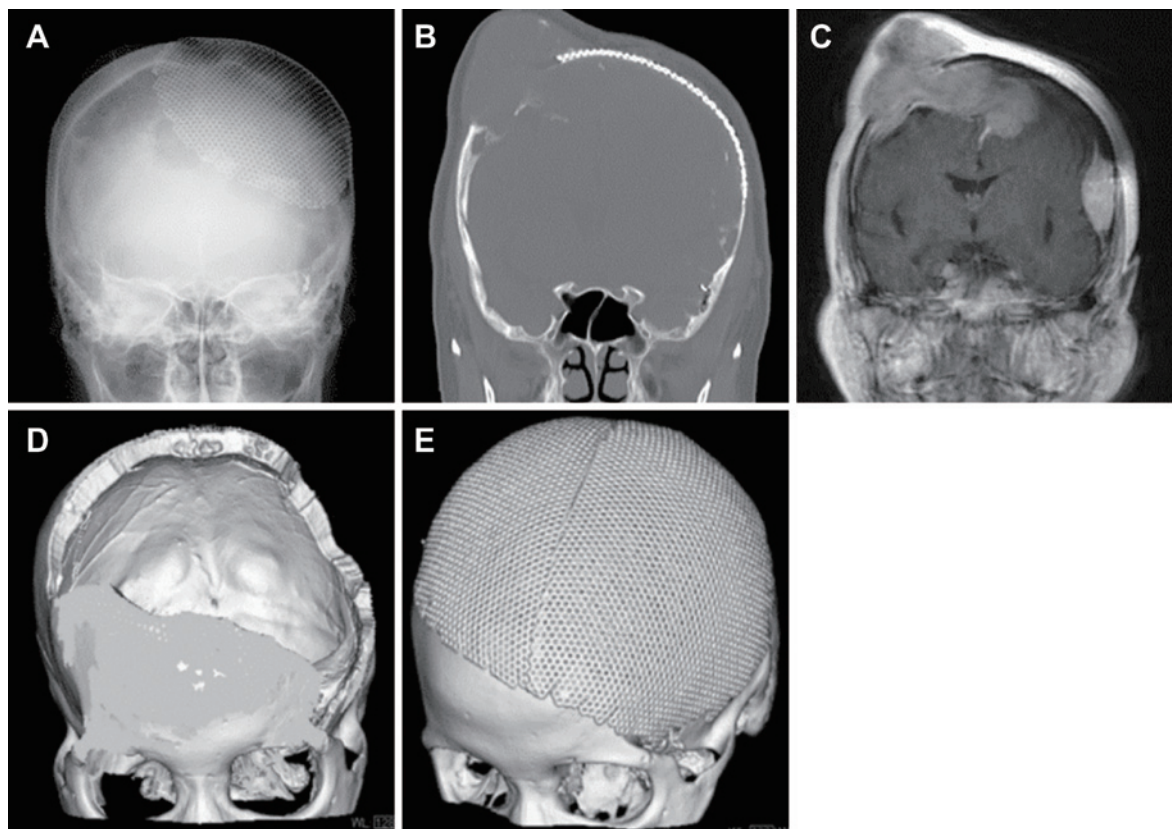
Radiographic findings at recurrence. A–C: Preoperative skull radiograph and CT scan displaying osteolytic lesions bilaterally at the site of the bone resection. Gd contrast-enhanced MRI displaying a large, heterogeneously contrasted mass with the extensive invasion of the craniotomy site, intradural and intracranial epidural spaces, and subcutaneous tissue. D, E: Postoperative CT scan exhibiting extensive removal of cranial bone and cranioplasty by titanium plate. CT; computed tomography, MRI; magnetic resonance imaging
